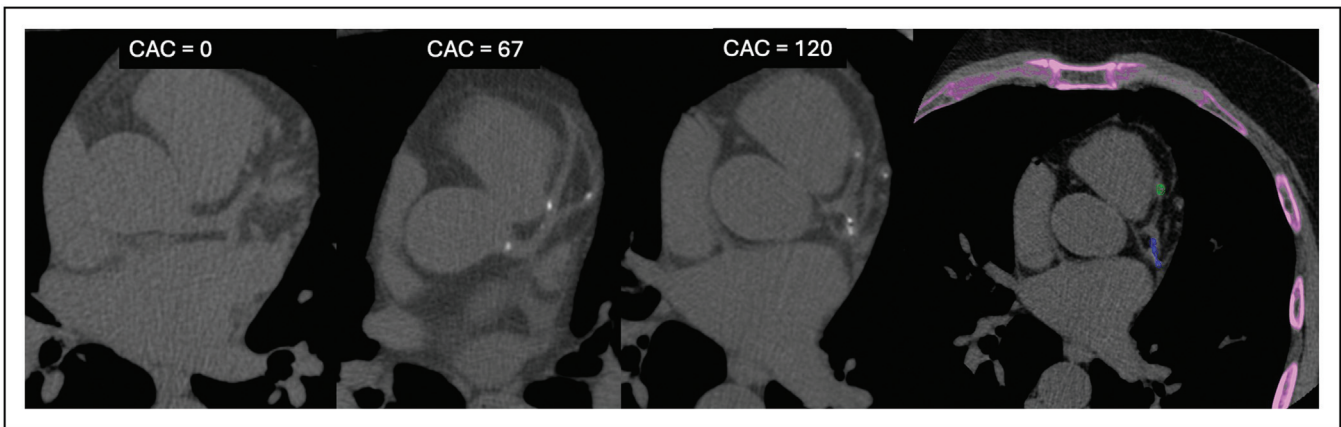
Noncontrast gated computed tomography images for coronary artery calcification reveal various grades of coronary calcifications (a–c). (d) displays an automated analysis using commercially available software (Vitrea), which highlights any structure attenuating at least 130 Hounsfield Units (pink in d). Regions of interest were subsequently placed around the calcifications in the coronary arteries, with distinct colors assigned to each segment for clarity, all performed manually.
